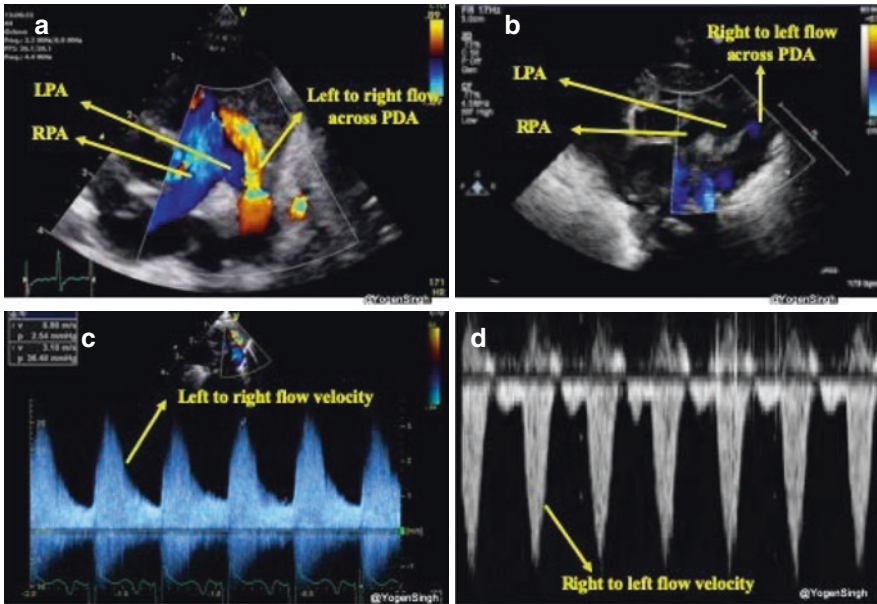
Assessment of PDA shunt direction on color flow and spectral Doppler. (a) Left to right shunt seen as red (blood coming towards probe) while blood in branch pulmonary arteries is seen as blue (blood going away from the probe); (b) right to left shunt seen as blue color—similar to branch pulmonary arteries in a view “three legged trouser”; (c) Pulsed Wave Doppler assessment showing
